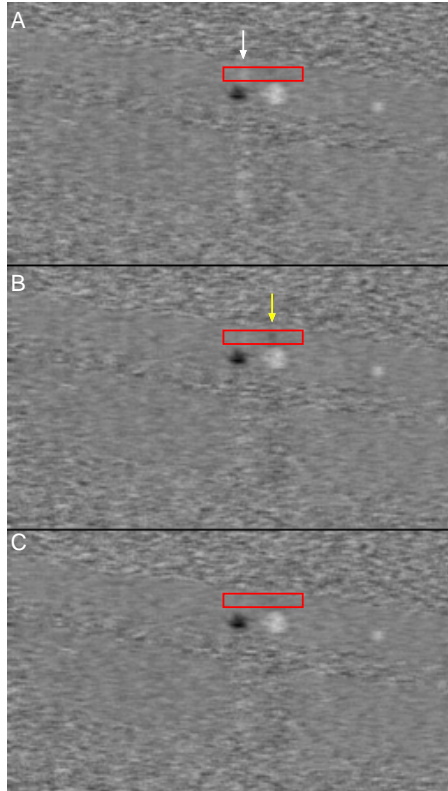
Comparison of the blood flow images after bulk motion elimination using different histogram bin width determination methods. Phase-noise-based method (A) and the Freedman & Diaconis rule (B), (C) are used to determine the histogram bin width. An averaged shifted histogram is used for (C). The white and yellow arrows indicate the bulk motion artifacts due to the estimation error. The images consist of 1024 axial scans and cover 1.5 mm in the transversal direction. The black and white colors denote Doppler shifts of -5.6 and +5.6 kHz, respectively.
